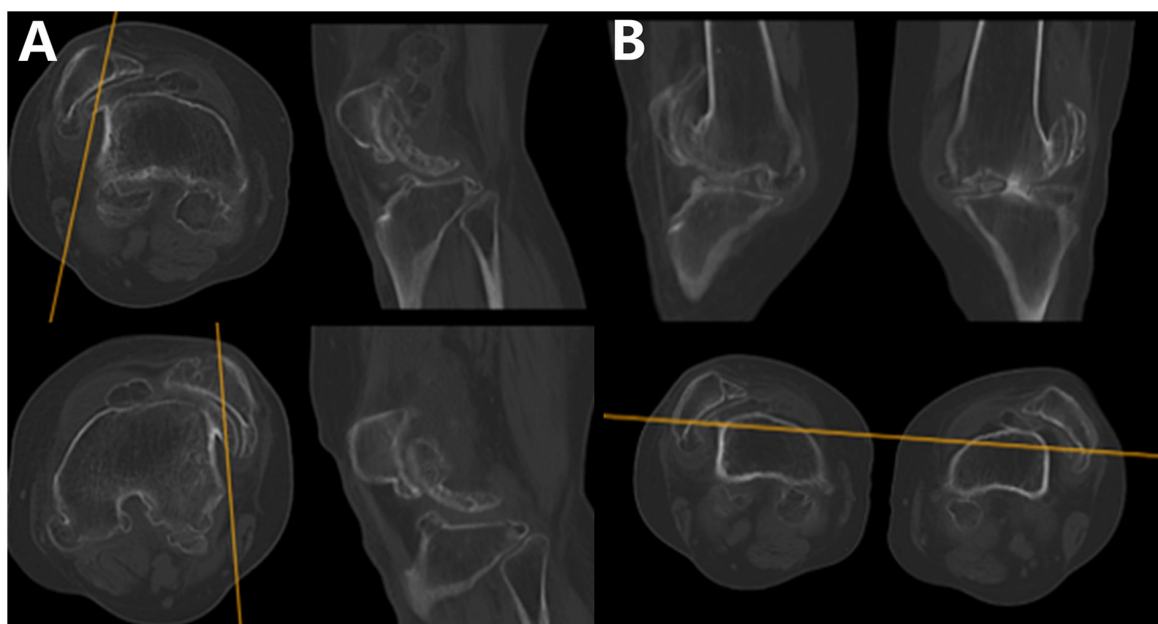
Preoperative knee CT scan. (A) CT scanning combining transverse and sagittal planes. (B) CT scanning combining transverse and coronal planes. Yellow lines are positioning lines along which reconstruction was performed. CT, computed tomography.
